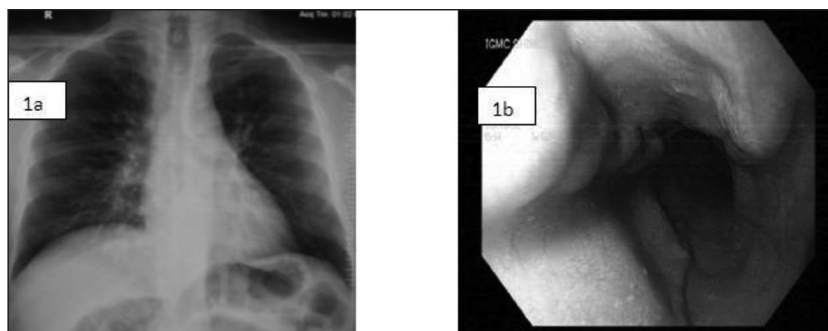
Chest X-ray of the patient which revealed normal study.
